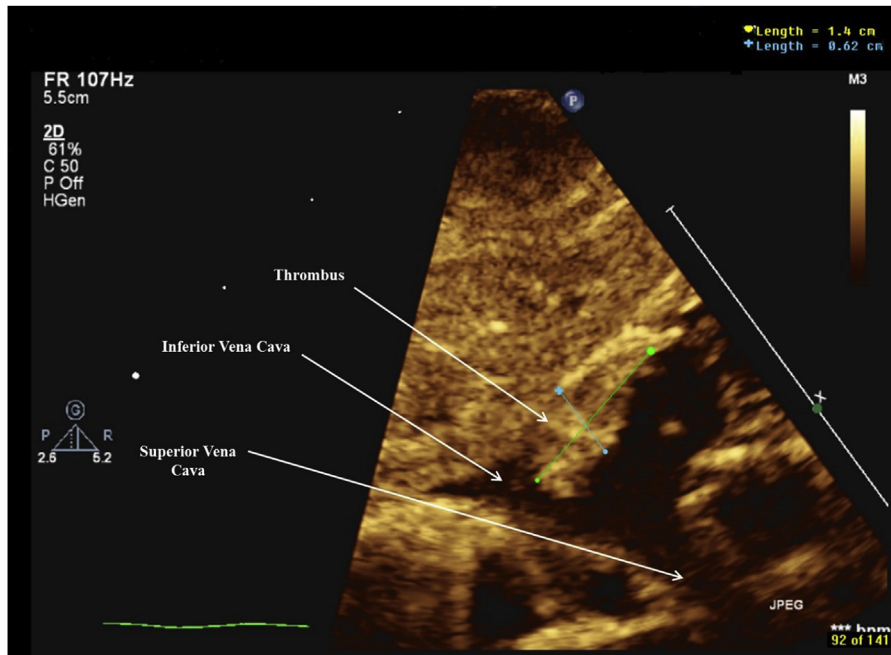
Echocardiography post-operative day 10.
